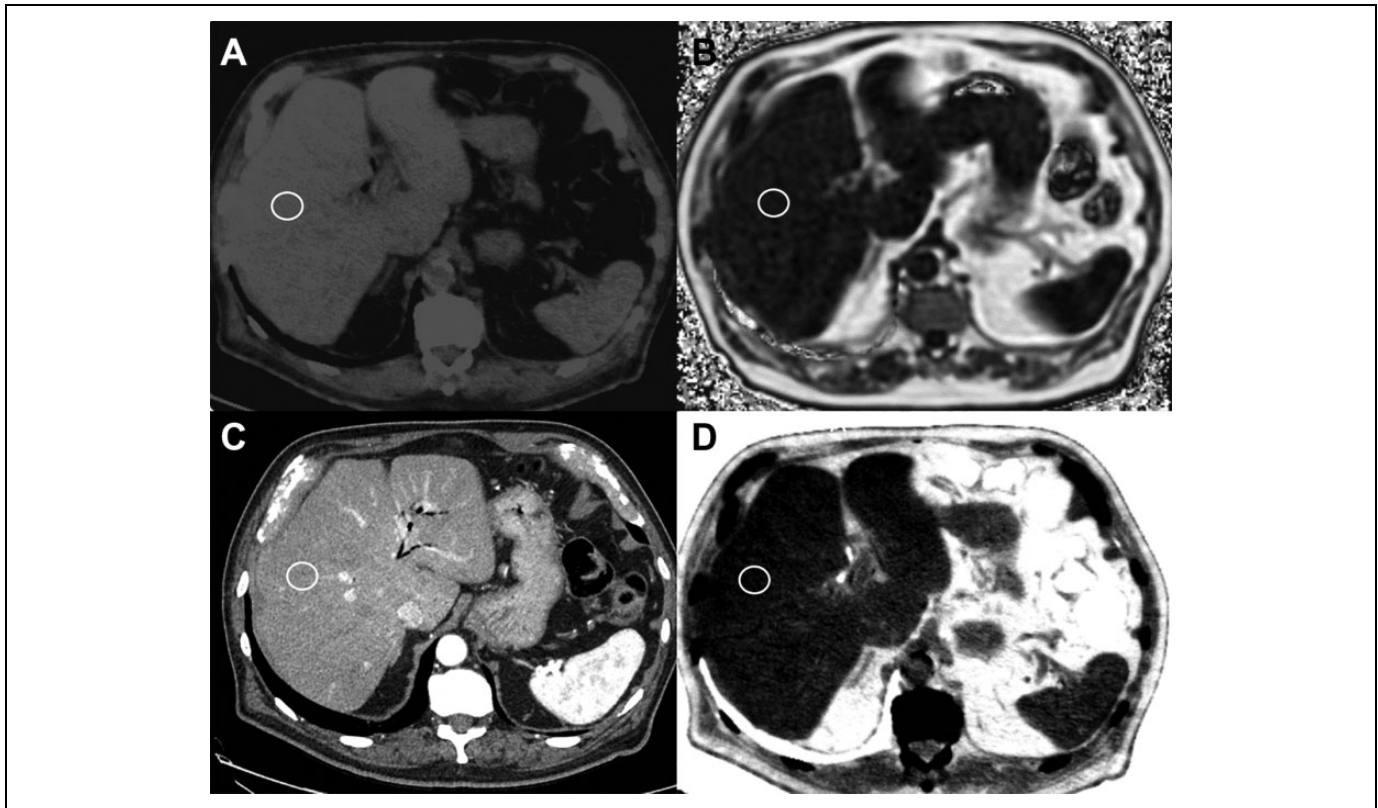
80-years-old male with bladder cancer patient with no known steatosis. ROIs traced in the right liver, avoiding major vessels and bile ducts. A) MRI IDEAL IQ sequence, $R2^* \setminus$ IRON map shows that there is no evidence of iron surcharge ($R2^* = 122.08$). B) MRI IDEAL IQ sequence, PDFF map shows no evidence of steatosis: PDFF = 3.3% normal values < 6.6%. C) Monochromatic DECT at 60keV. The placed ROI at the level of the VI hepatic segment shows an HU of 85. D) FVF map. An ROI placed in the same point as in C gives back a calculated FVF of 5.5%.
